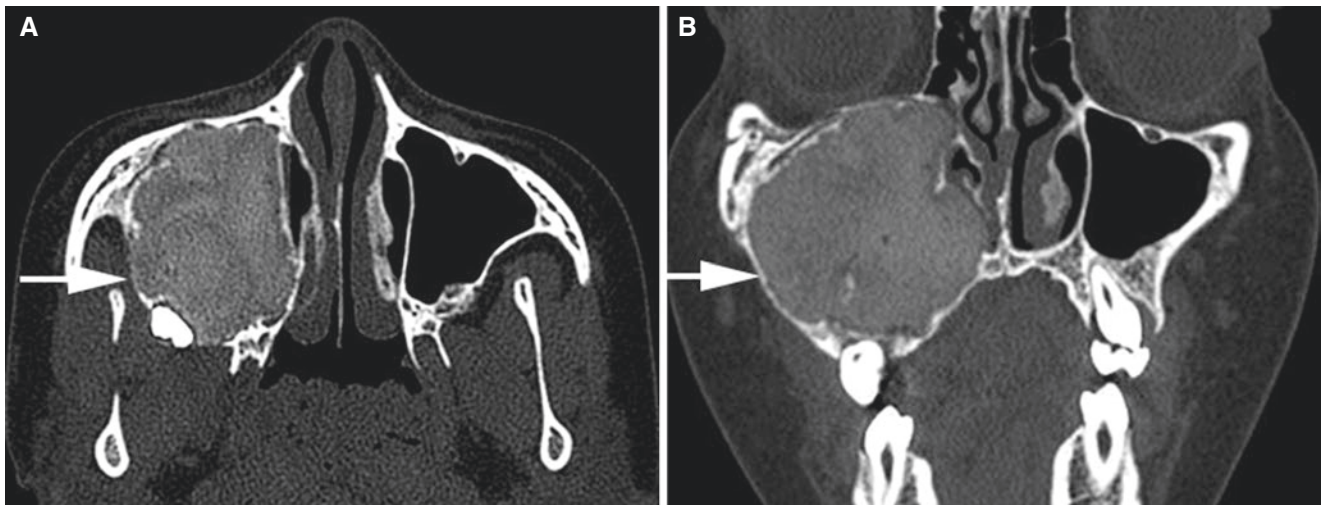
Juvenile ossifying fibroma, maxilla/maxillary sinus; 10-year-old female with pain-free swelling of the right maxilla/maxillary sinus. (A) Axial and (B) coronal CT images show expanding radiopaque mass
